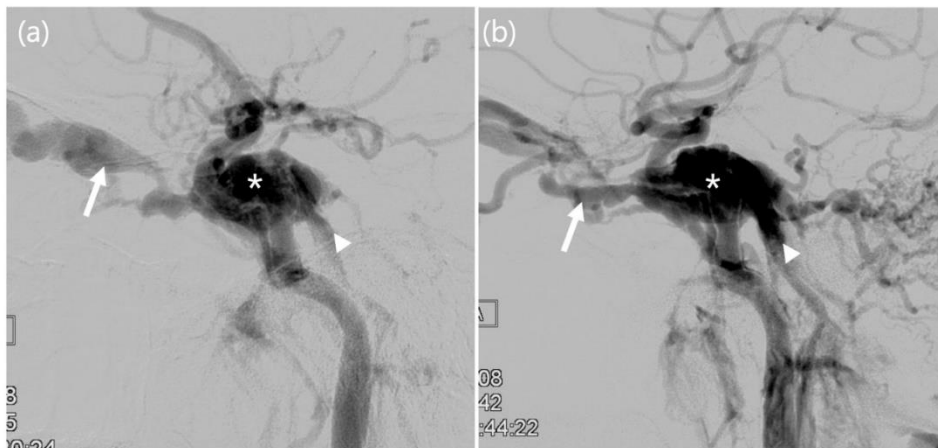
Brain CT angiography revealed (a) right side (b) left side direct carotid-cavernous fistulas (asterisks), draining anteriorly to the SOVs (arrows), and posteriorly via the inferior petrosal sinus (arrowheads)
